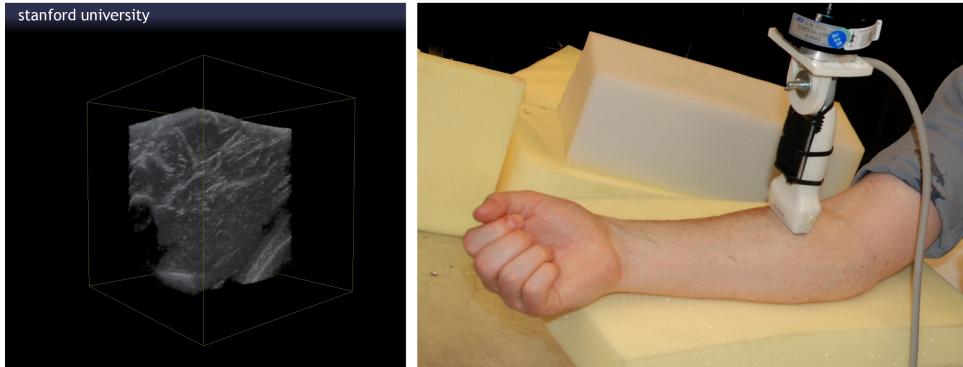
Ultrasound examination of the arm (Left) Generated 3D model. (Right) Ultrasound transducer mounted on a PUMA manipulator.
